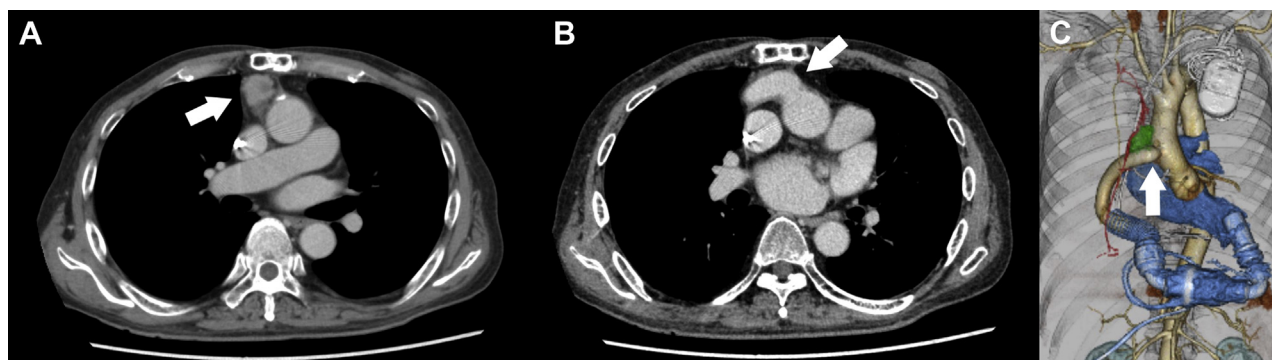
Diagnostic CT images before the surgery. (A) Axial view of CT (white arrow, thymic carcinoma). (B) Axial view of CT revealing the graft and anastomotic region (white arrow). (C) Reconstructed image of CT (green object, thymic carcinoma on the outflow graft of the LVAD; white arrow, the anastomotic region between the outflow graft and ascending aorta). CT, computed tomography; LVAD, left ventricular assist device.
